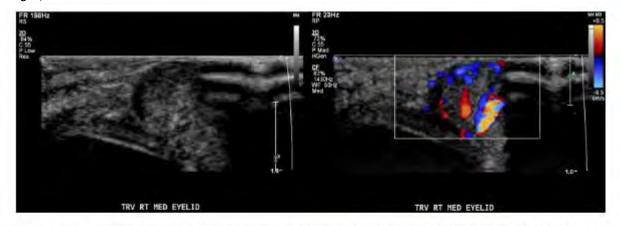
Transverse view of right upper eyelid. (Left) Gray-scale ultrasound. (Right) Color Doppler ultrasound.
